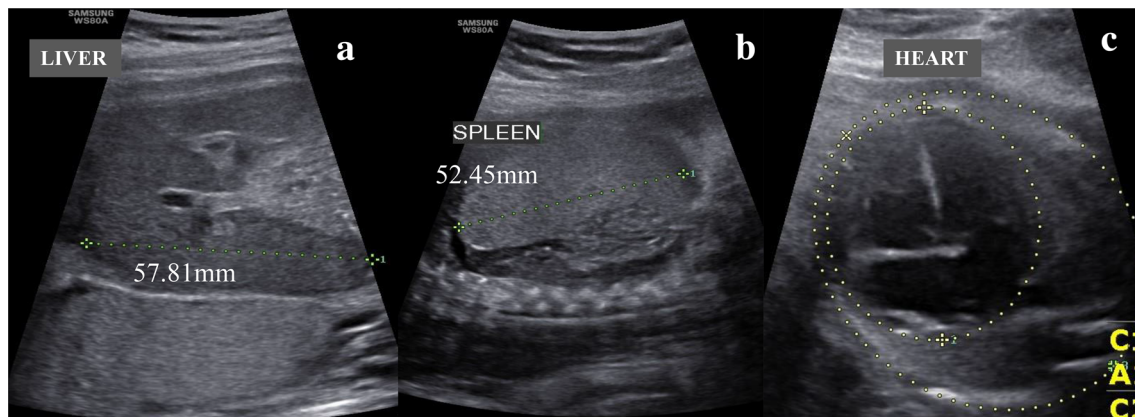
Ultrasound images of fetus showing a hepatomegaly, b, splenomegaly c cardiomegaly
